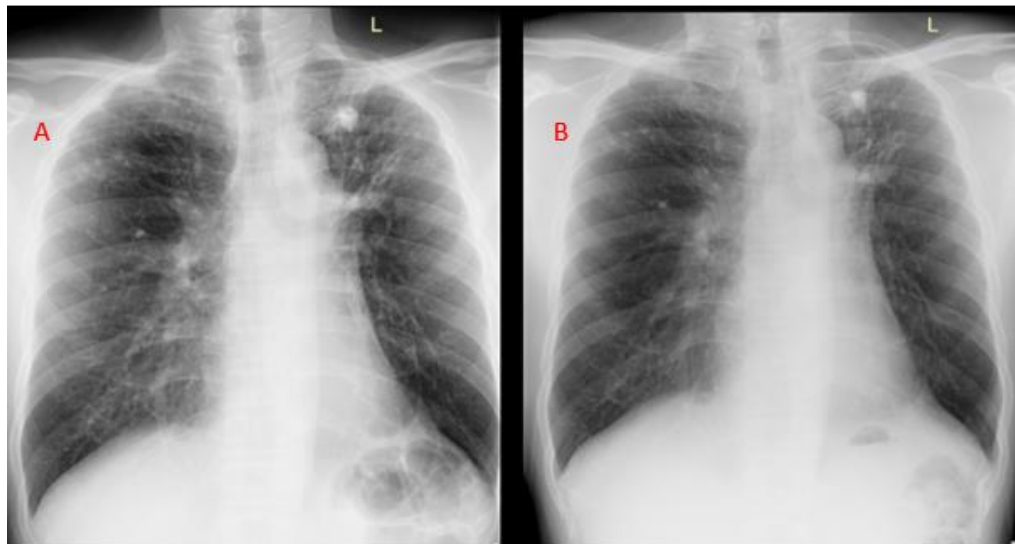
Follow-Up Chest X-Ray
